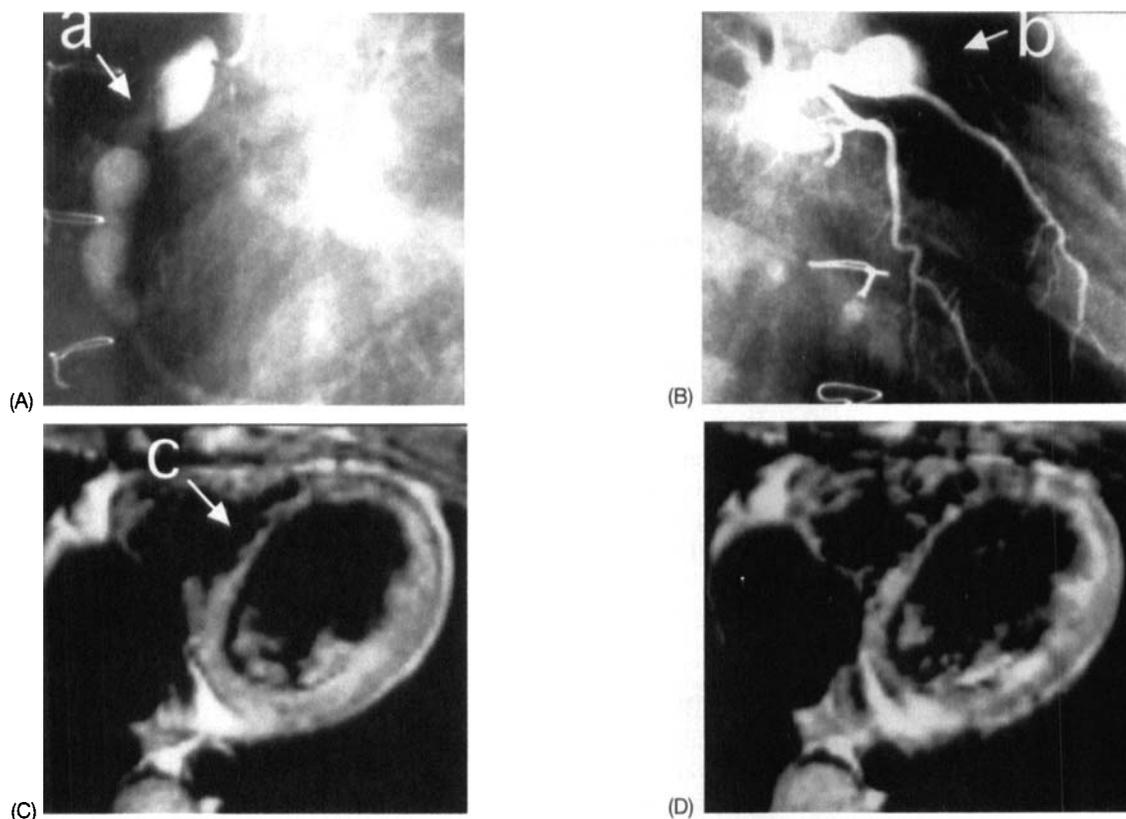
Case No. 1 (18-year-old girl): Coronary angiography at 1 year and 3 months after onset of acute myocardial infarction (AMI) (A and B) and magnetic resonance imaging at 1 year and 4 months after onset of AMI (C and D). There is localized stenosis in the right coronary artery (arrow a). Complete occlusion is observed in left anterior descending artery (arrow b), and no evident collateral circulation is found (B). Marked thinning is observed in interventricular septum and anterior wall of the left ventricle (arrow c). After injection of gadolinium diethylenetriamine pentaacetic acid, enhancement is not found (D).
